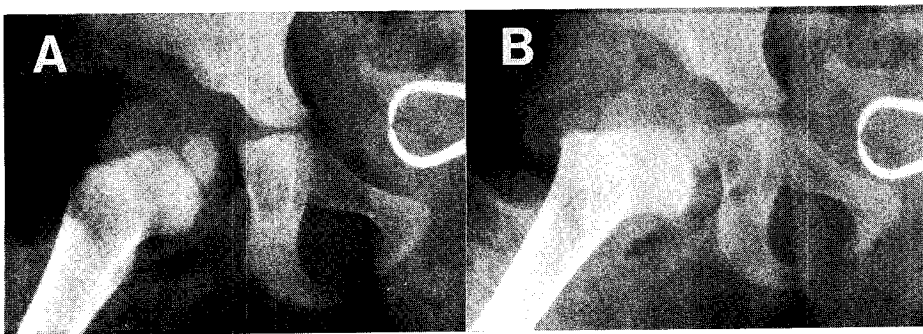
Radiographic view of concentration by our procedure. A : When an attempt is made to reduce the femoral head before the joint capsule is incised circumferentially near the acetabular rim, a concentric reduction can not be made within the acetabulum. B : After dissection of the whole capsule, the femoral head is reduced satisfactorily.
